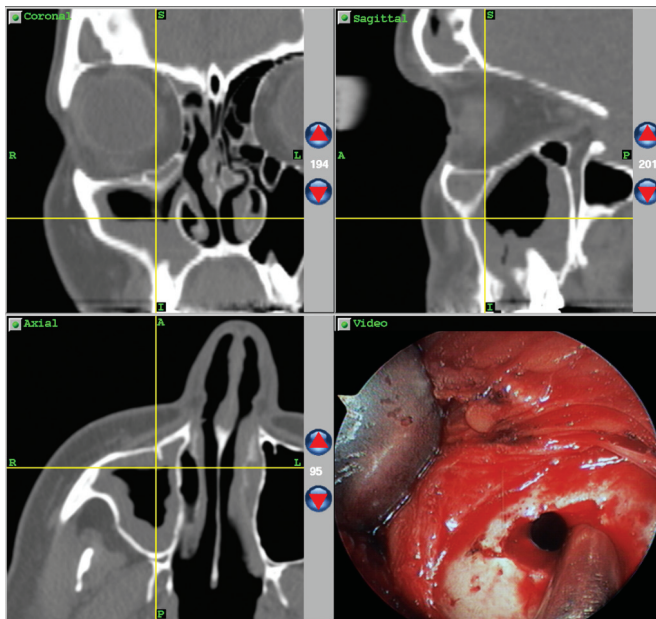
Caldwell-Luc procedure. Computed tomography image guidance demonstrates the location of the tip of the straight suction within the right maxillary sinus during a Caldwell-Luc procedure for recurrent inverting papilloma of the right maxillary sinus floor and lateral wall in the setting of chronic maxillary sinusitis. Endoscopic image shows the intraoral approach with the straight suction inserted through the surgically created defect in the anterior maxillary sinus wall.
